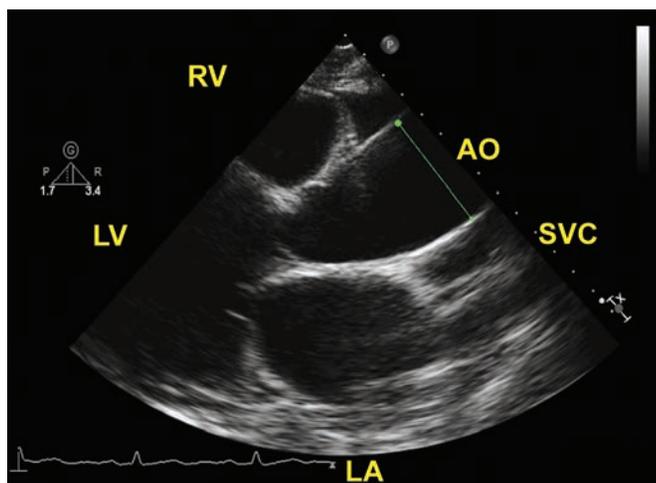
Parasternal long axis view. The ascending aorta is enlarged and measures 4.0 cm.
